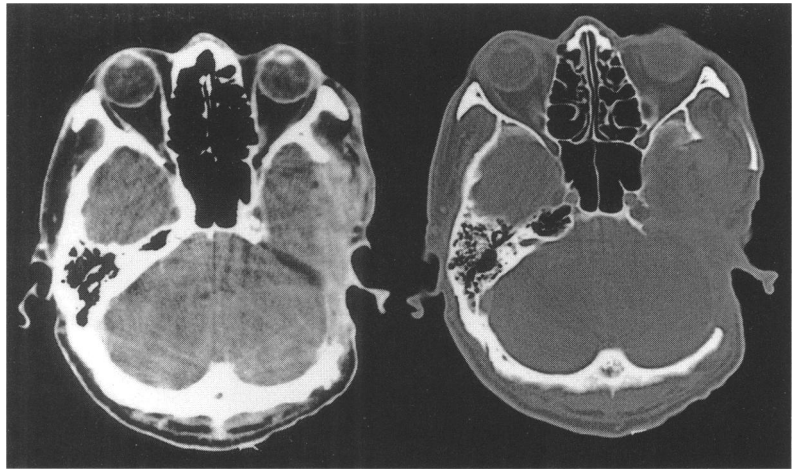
Case 1: postoperative computed tomography. Petrous apex was resected.
